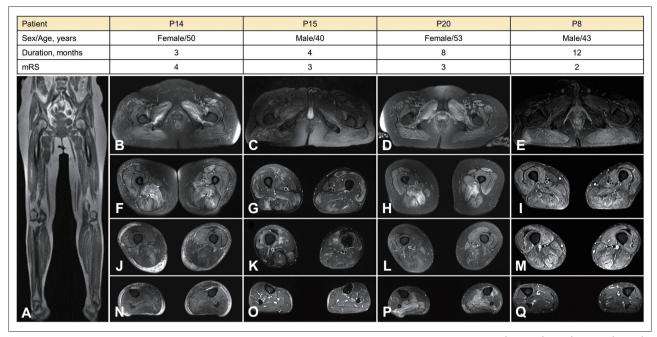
Short-tau inversion-recovery MRI of the lower limb in patients with anti-SRP54 antibodies: patients P14 (B, F, J, N), P15 (C, G, K, O), P20 (A, D, H, L, P), and P8 (E, I, M, Q). A: T1-weighted coronal MRI of the lower limb. B-E: Pelvis-level images revealed predominant edema of the obturator externus and gluteus maximus muscles. F-M: Thigh-level images revealed multifocal or diffuse edema of the entire thigh muscles, particularly in the adductor magnus muscles. N-Q: At the calf level, two patients (shown in panels N and P) had muscle edema in the tibialis anterior, soleus, and gastrocnemius muscles. anti-SRP, anti-signal-recognition particle; MRI, magnetic resonance imaging; mRS, modified Rankin Scale.
